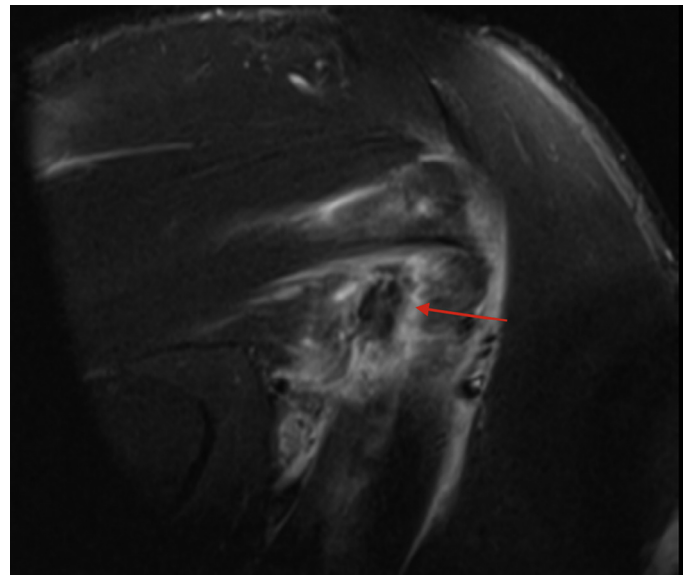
Coronal magnetic resonance imaging study with the arrow pointing to an isolated teres minor tear.
